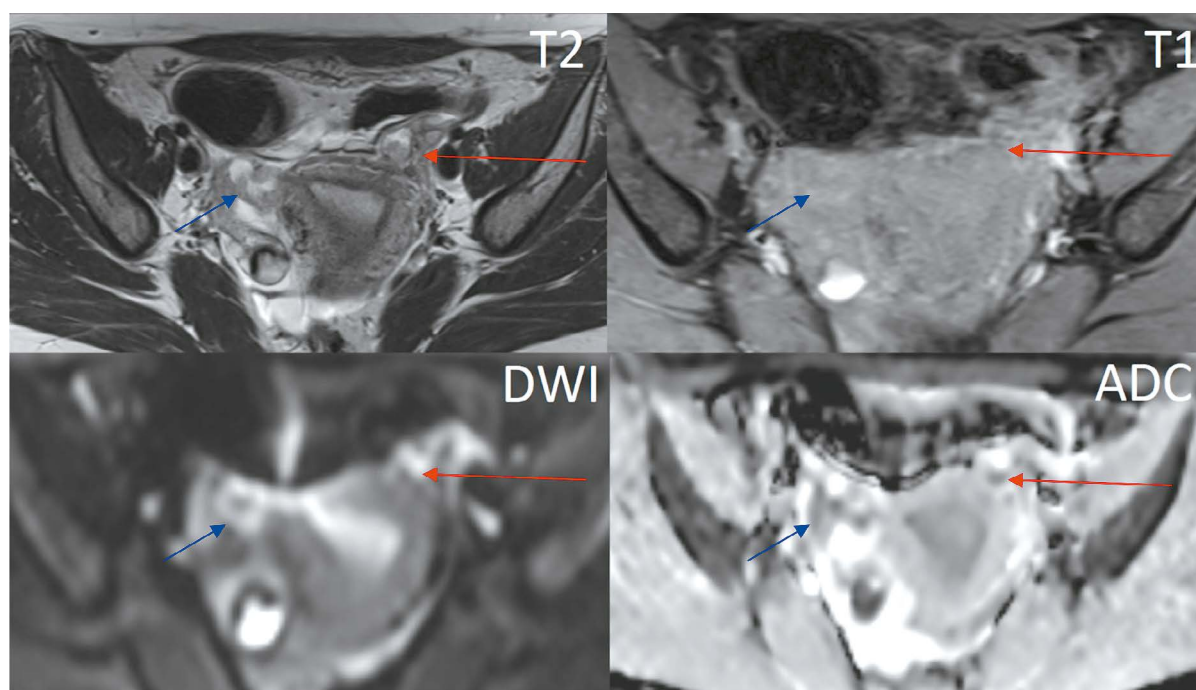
Pelvic magnetic resonance imaging (axial view). Similar solid nodules are present in the left fallopian tube (red arrow). The right fallopian tube appears convoluted in this slice (blue arrow).
